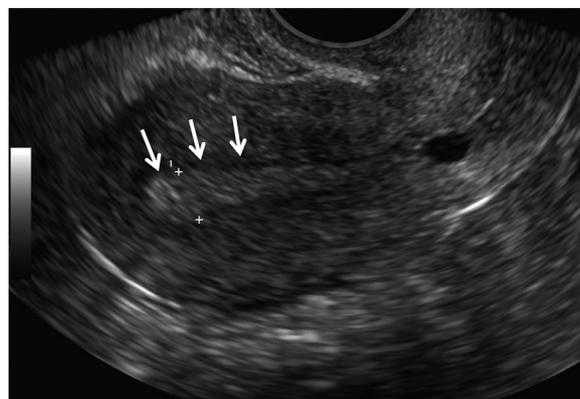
75-year-old female with postmenopausal bleeding. (A) Transvaginal sagittal ultrasound image of the uterus demonstrates a thickened homogeneous endometrium measuring 9 mm cm (arrows). Note regular endometrial-myometrial border with no signs of invasion (arrows). Endometrial biopsy was performed with the diagnosis of endometrial cancer.
